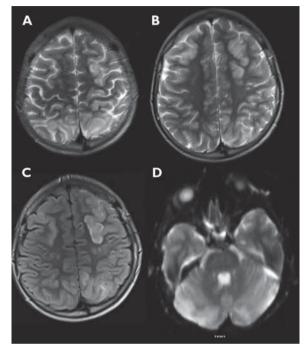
Typical appearances of ciclosporin neurotoxicity. Note that in this case changes are relatively asymmetric and not confined to occipital cortex (c.f. PRES, see III p. 524). T2 sequences top (A and B); FLAIR sequence (C), and DWI (D).
